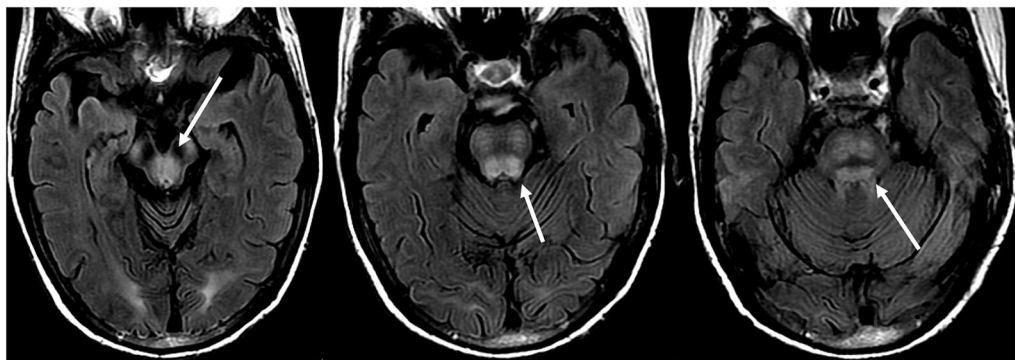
Patient with a history of liver transplantation two weeks earlier on Tacrolimus. T2-FLAIR images show signal abnormality within the midbrain, pons, and superior cerebellar peduncles.
